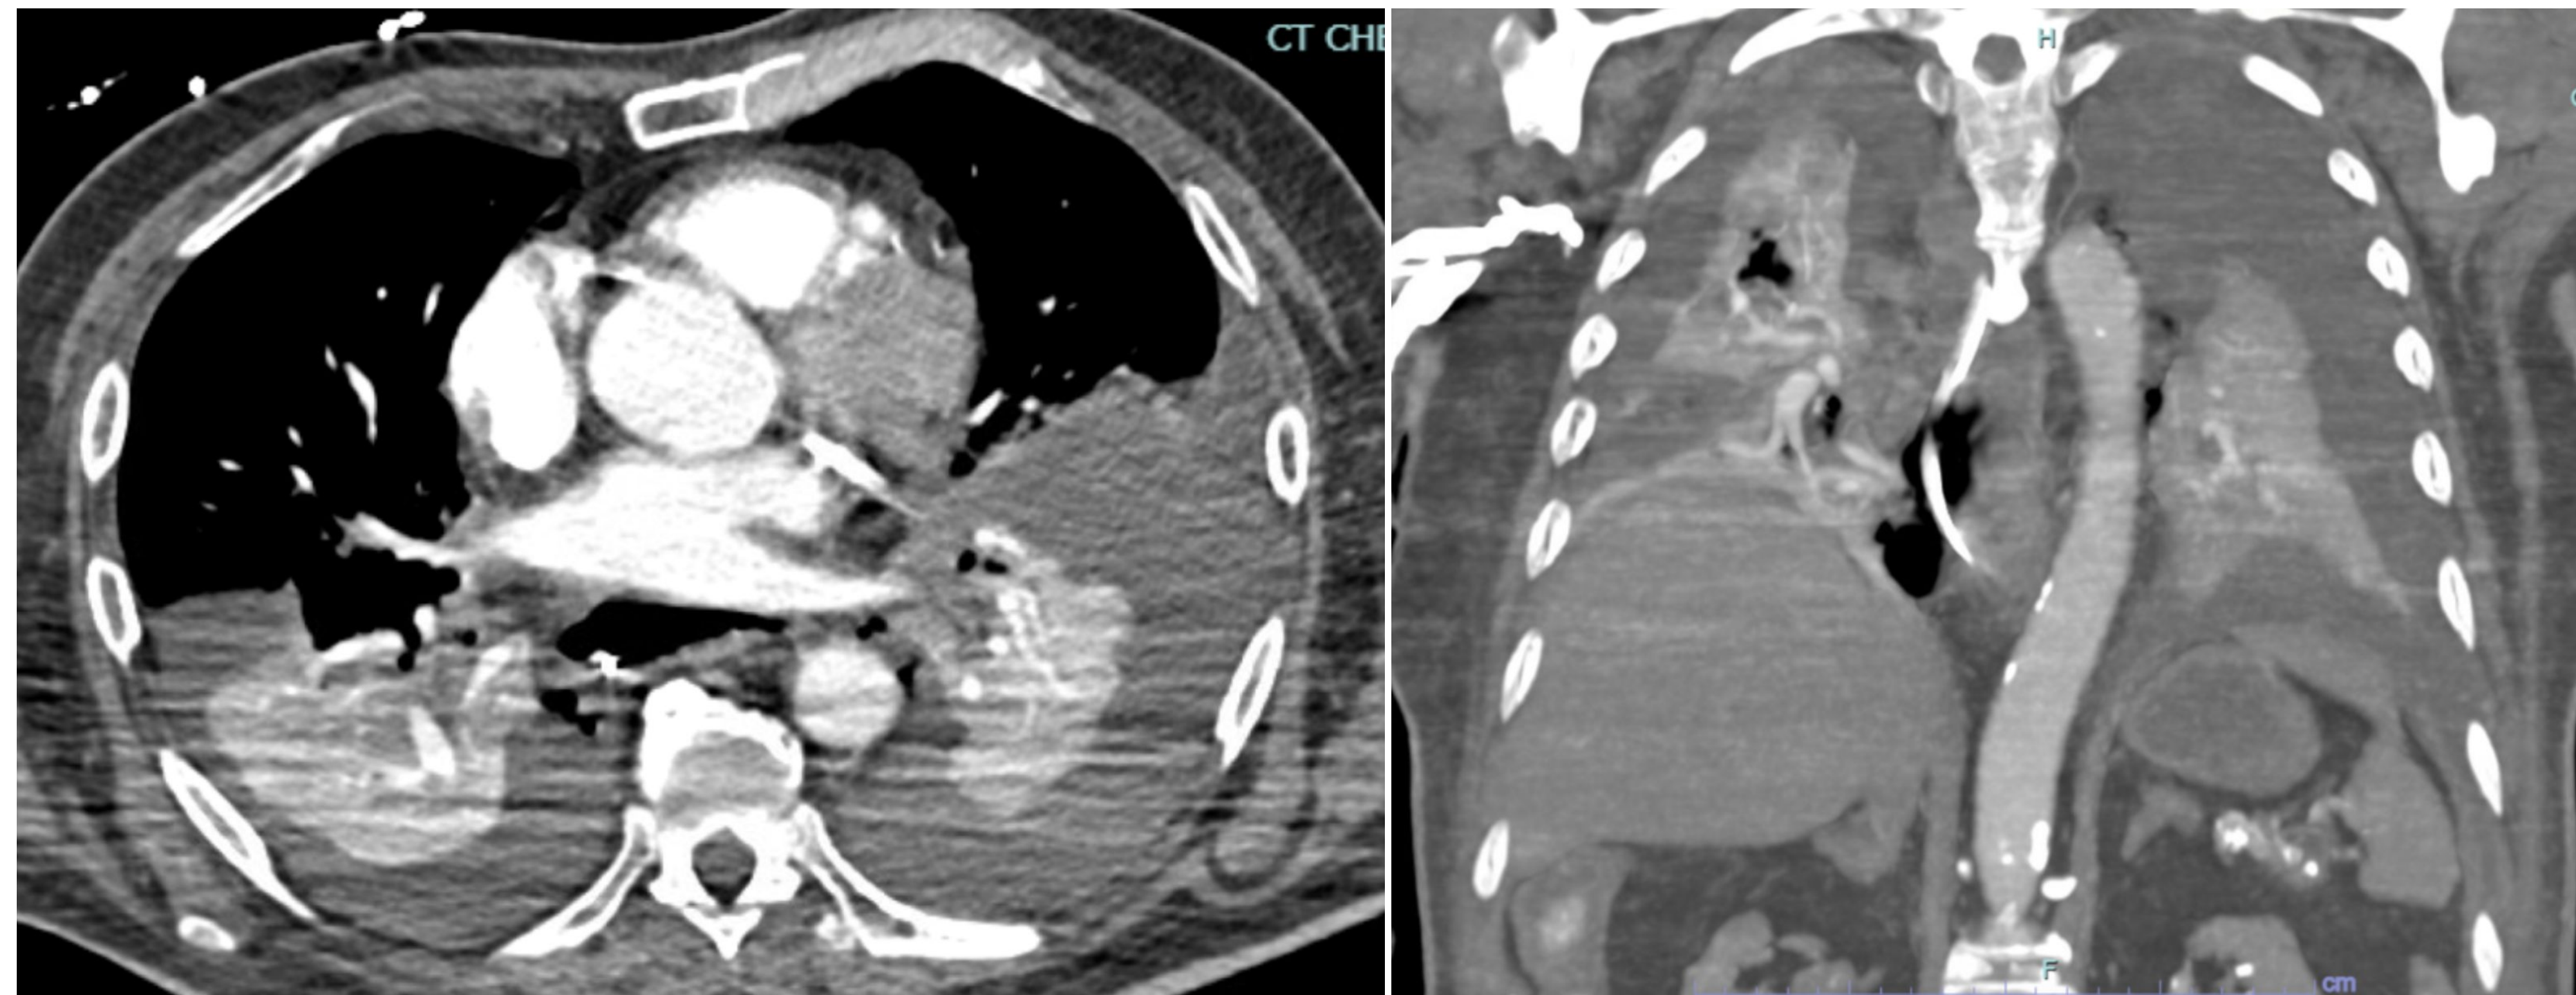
CT abdomen pelvis revealing esophageal perforation with large bilateral pleural effusions, pneumomediastinum, and a posterior mediastinal collection.
